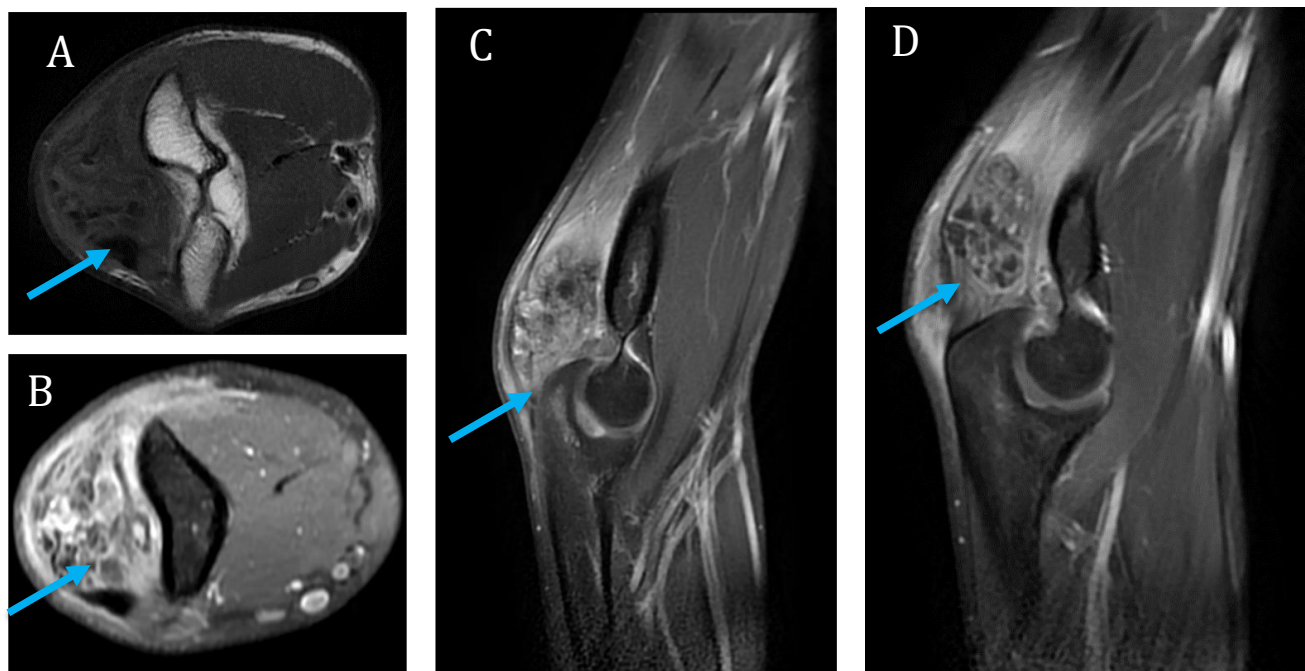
Right elbow MRI: Axial T1 (A); Axial (B) and Sagittal (C, D) T1 fat-saturated contrast MRI showing heterogeneous contrast enhancement of the soft-tissue elbow mass
